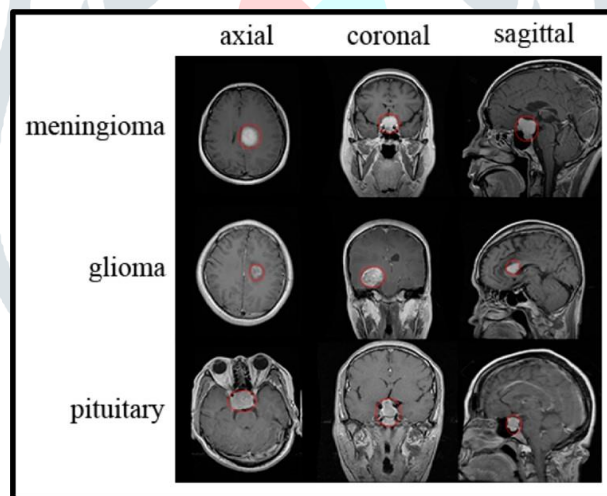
Representation Of MRI through spatial analysis
